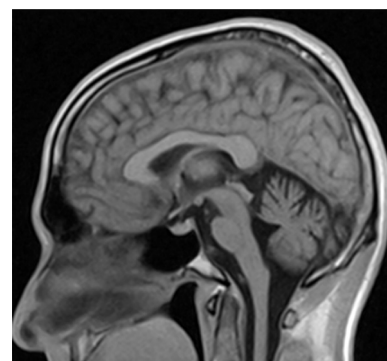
Sagittal T₁ brain MRI disclosing cerebellar and brainstem atrophy. This imaging finding is frequently seen in SCA2.
